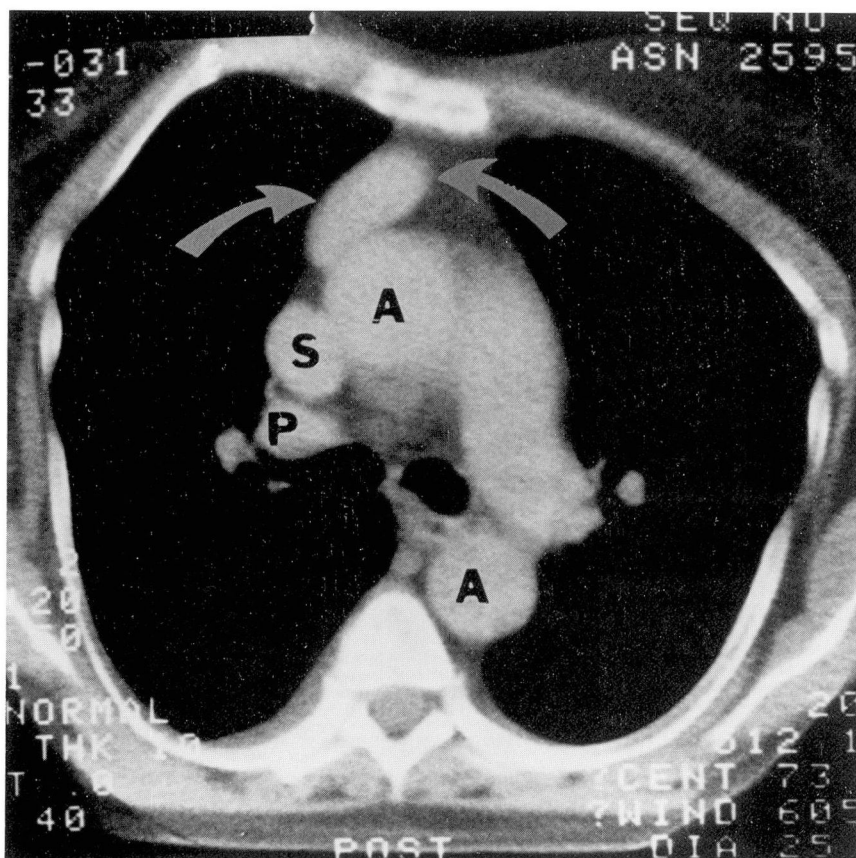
CT scan of the upper mediastinum. A well-defined mass is identified in the anterior mediastinum (arrows), just anterior to the ascending aorta (A). S = superior vena cava; P = right pulmonary artery.
